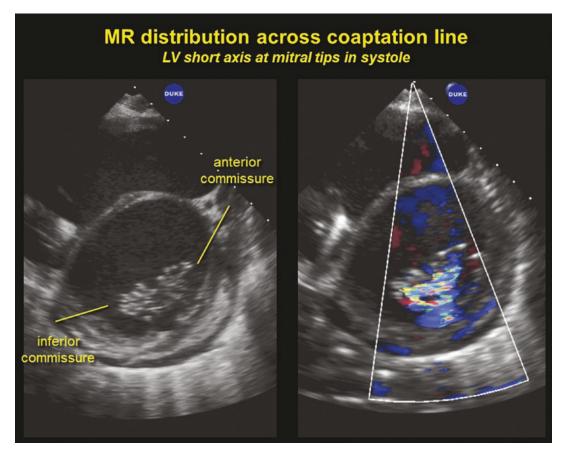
Short axis parasternal view of a closed mitral orifice in a patient with a dilated cardiomyopathy and mitral regurgitation. Using color flow, the mitral regurgitation can be seen along the entire mitral coaptation line (right panel)
